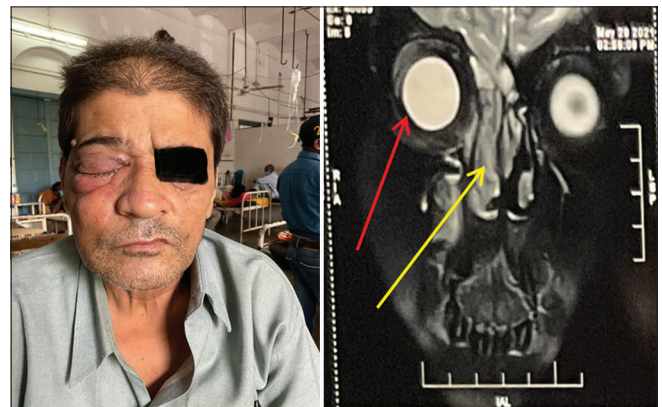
Proptosis, ptosis, and chemosis of the right eye. In T2W MRI, coronal section at the level of orbit shows proptosis of the right globe with surrounding inflammatory changes (red arrow). The right nasal cavity is filled with T2 isointense contents which are abutting superiorly the cribriform plate and laterally medial wall of orbit (yellow arrow)
